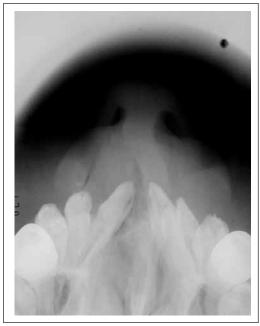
Case 2. Upper standard occlusal radiograph.
